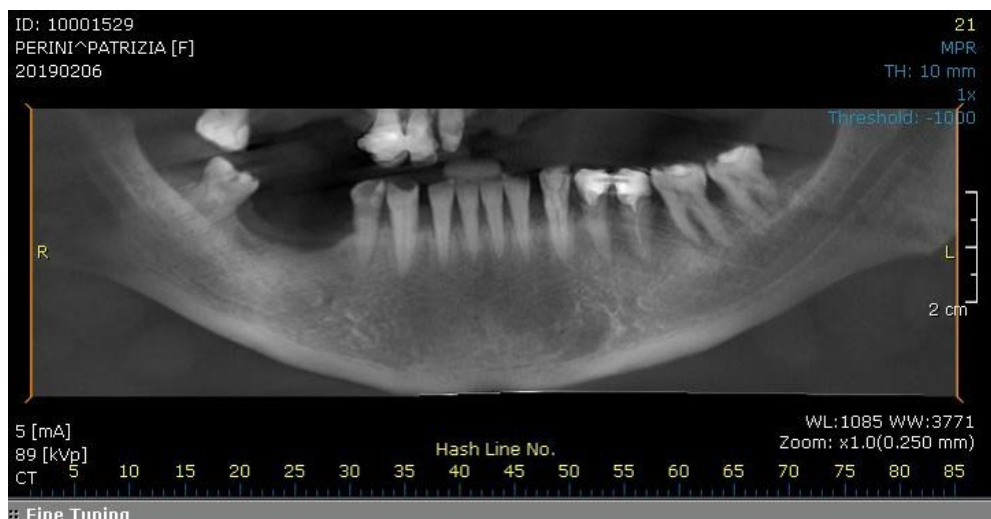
TC Cone Beam pre-surgical site, Panorex.
